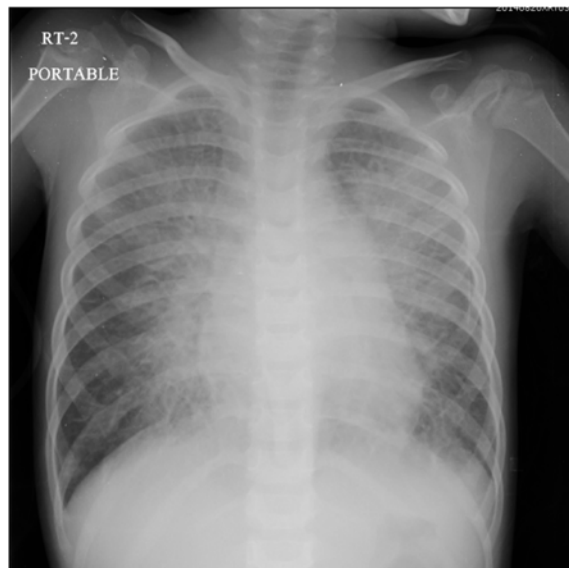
Chest radiograph showed pulmonary edema without cardiomegaly.
